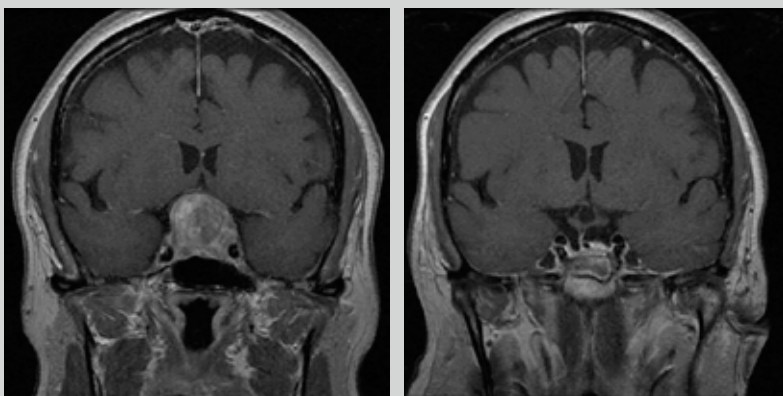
MRI scans from a 64-year-old woman presenting with a history of progressive bitemporal vision loss. On the left, a preoperative coronal MRI demonstrates a large pituitary tumor with suprasellar extension. The optic chiasm is markedly compressed, and tumor is abutting the bilateral carotid arteries. On the right, postoperative coronal MRI after endoscopic surgery demonstrates complete resection of the tumor. The optic chiasm is well decompressed, and the pituitary stalk is intact. Packing is visible in the sphenoid sinus below the sella.
